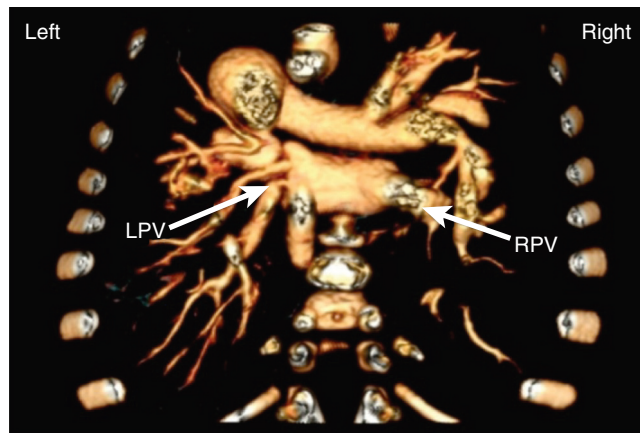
■ CT reconstruction of congenital pulmonary vein stenosis: from a posterior view of the chest the reconstruction shows diffuse stenosis of the left pulmonary veins (LPV; arrow) upper compared to unobstructed right lower pulmonary vein (RPV; arrow). Right upper pulmonary severe stenosis is not visualized in this projection.
